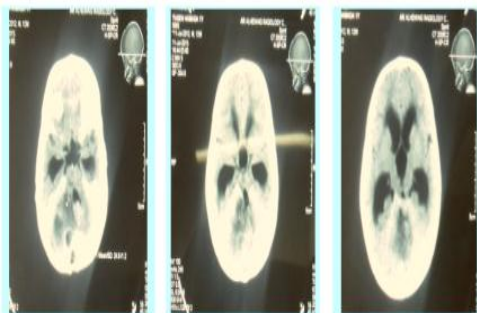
A: Preoperative CT
